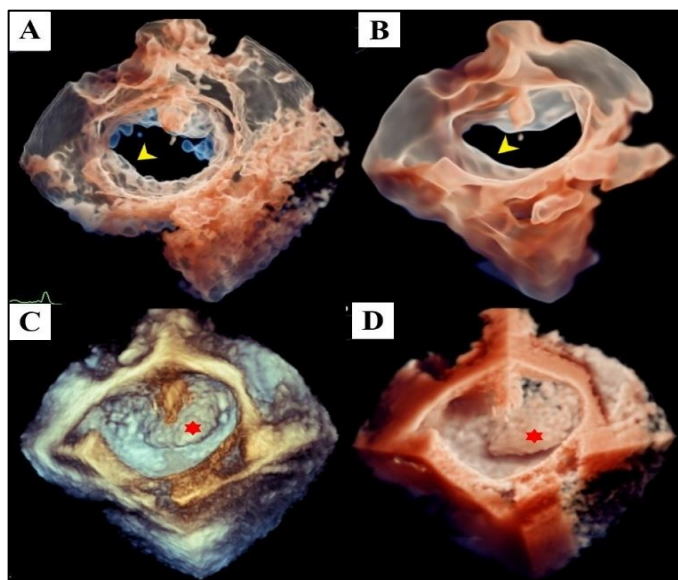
3-dimensional transesophageal echocardiography images demonstrate hypoplastic posterior mitral leaflet with rudimentary tissue in the region of P1 scallop (yellow arrowhead) along with muscular continuation (A, B), anterior mitral leaflet (A2, A3 scallops- red star) seen prolapsing (C, D).
